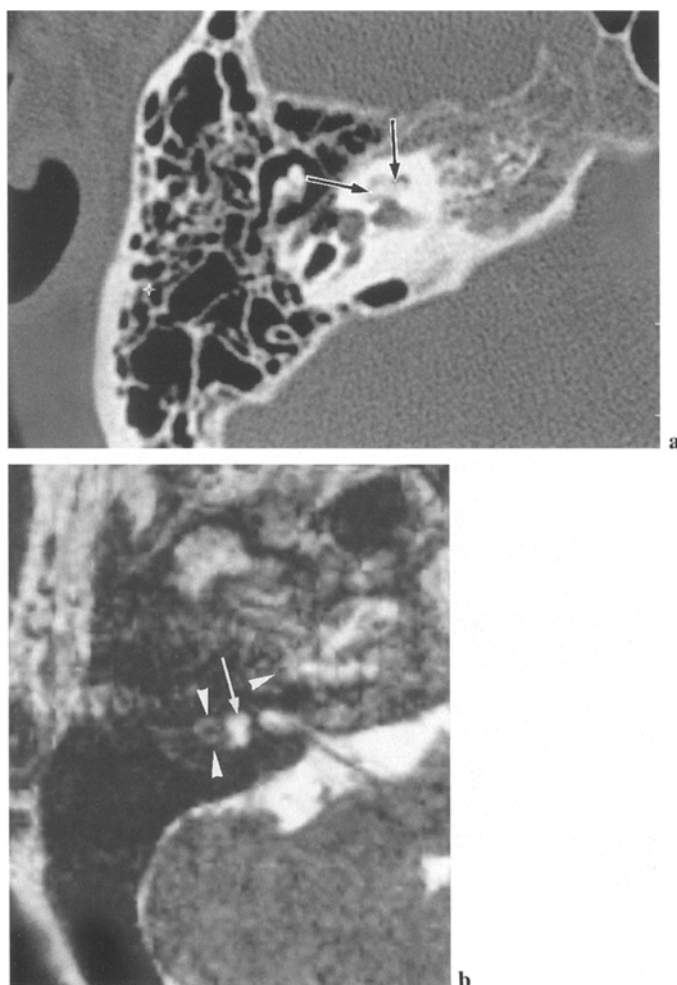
a CT shows cochlear calcifications (*arrows*). b T2WI MR shows a complete absence of the SI of the anterior labyrinthine structures and of the lateral and the posterior semicircular canals (*arrowheads*) sparing the lumen of the vestibule (*arrow*): postbacterial calcified labyrinthitis
